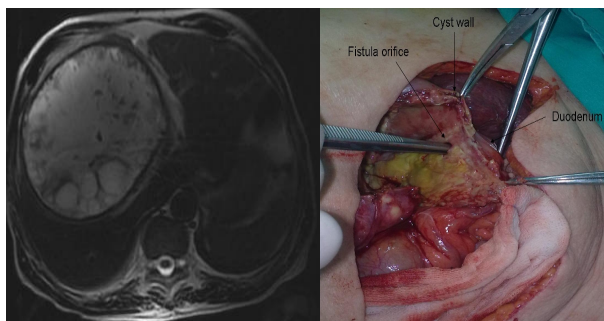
MR image of the cyst and intraoperative image of the cyst
